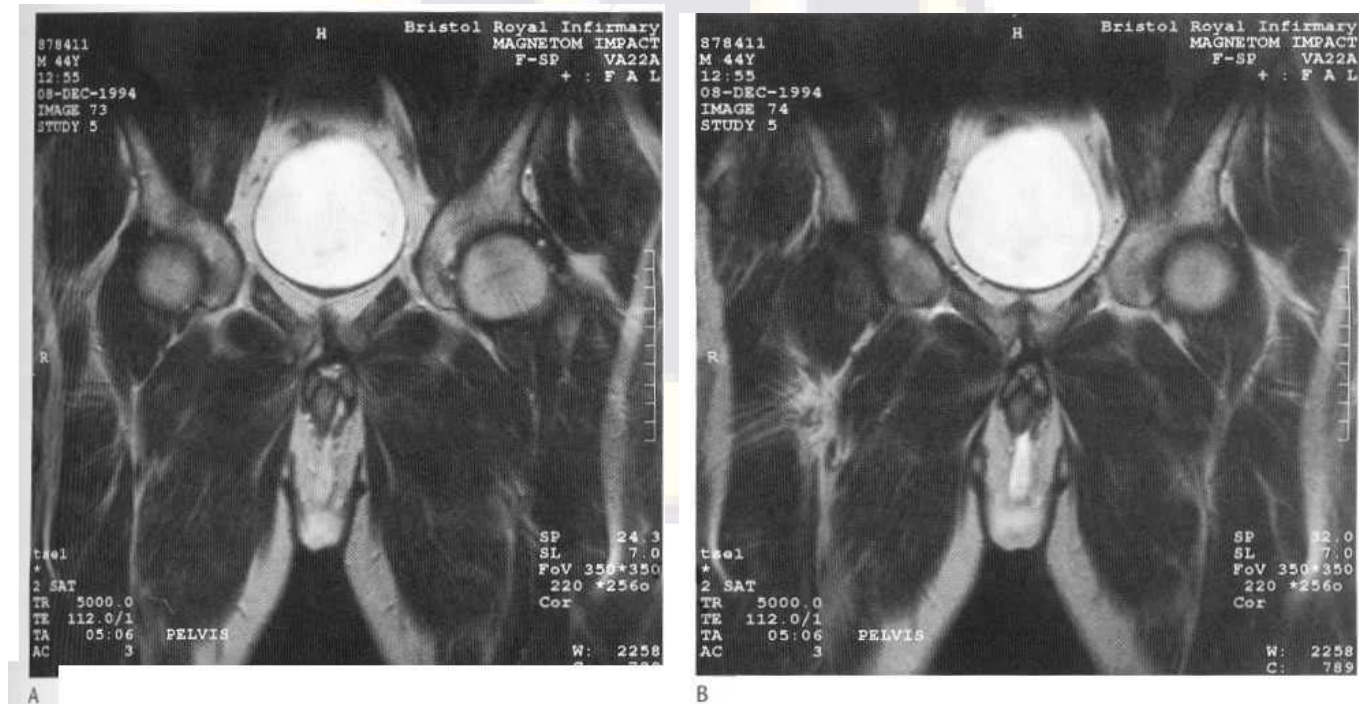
Coronal T₂-weighted MR image showing a sinus from the base of the penile urethra down into the scrotum.
